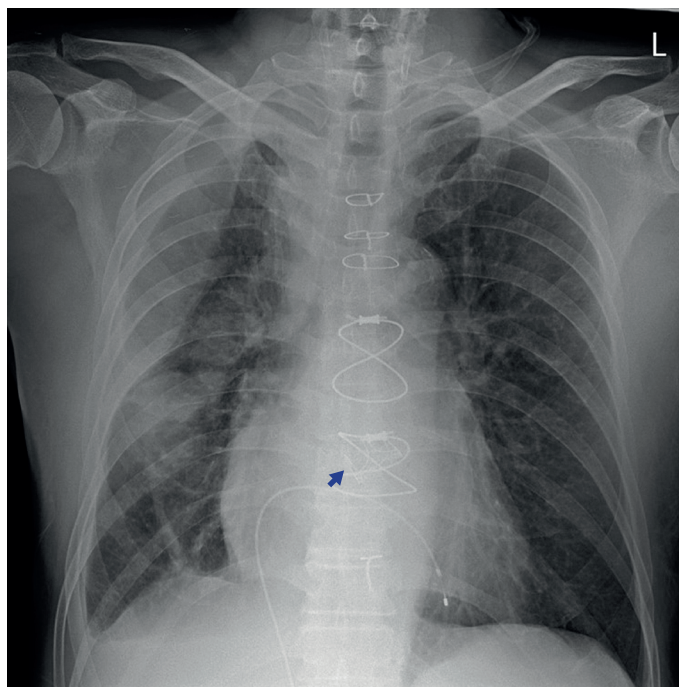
Chest X-ray image. Radiography showed pulmonary infiltrates in the right middle lung field and pleural effusion. Temporary pacemaker lead and bioprosthetic aortic valve (arrow) were seen.
